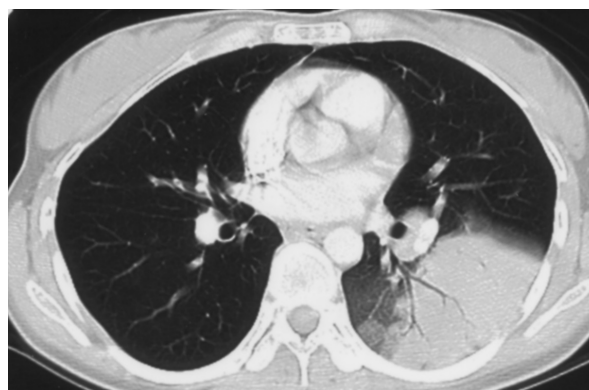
Chest CT was performed because of the poor response to antibiotic treatment after admission, and revealed lobar consolidation of the left lower lobe with an obvious air-bronchogram.
